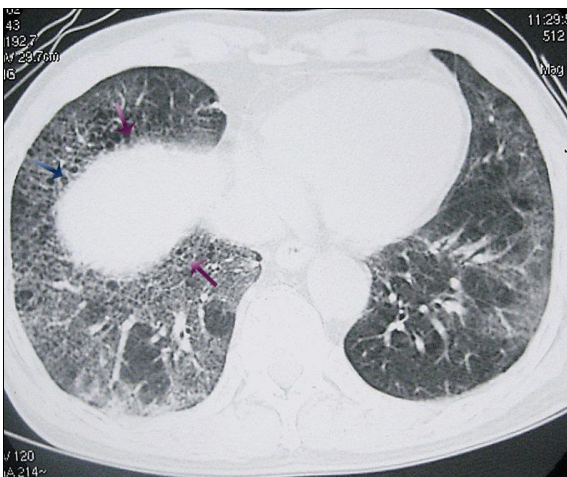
axial lung base CT at the costophrenic angel level
